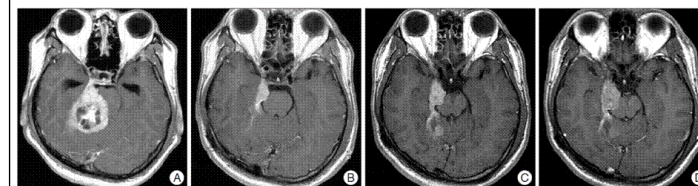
Axial T1-weighted gadolinium-enhanced magnetic resonance (MR) images of patient 8 in Table 1, 2. A : Preoperative MR image demonstrating an enhancing mass lesion at the petrous apex with brainstem compression. B : Postoperative MR image demonstrating a remained mass lesion at petrous apex. C : MR image at 42 months after the operation demonstrating increased the mass. Hydroxyurea was started. After then, the tumor had been a stable disease. D : MR image at 89 months after initiation of hydroxyurea treatment demonstrating more increase the tumor and midbrain was compressed by tumor mass.
